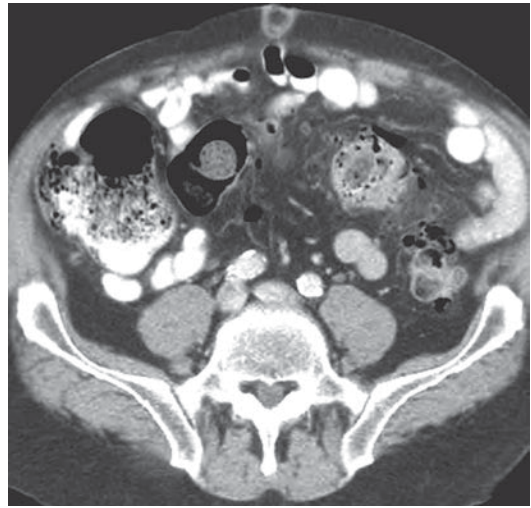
CT demonstrates acute diverticulitis with inflammation and fat stranding in addition to microperforation of the colon. Such patients are more likely to have recurrent diverticulitis.
